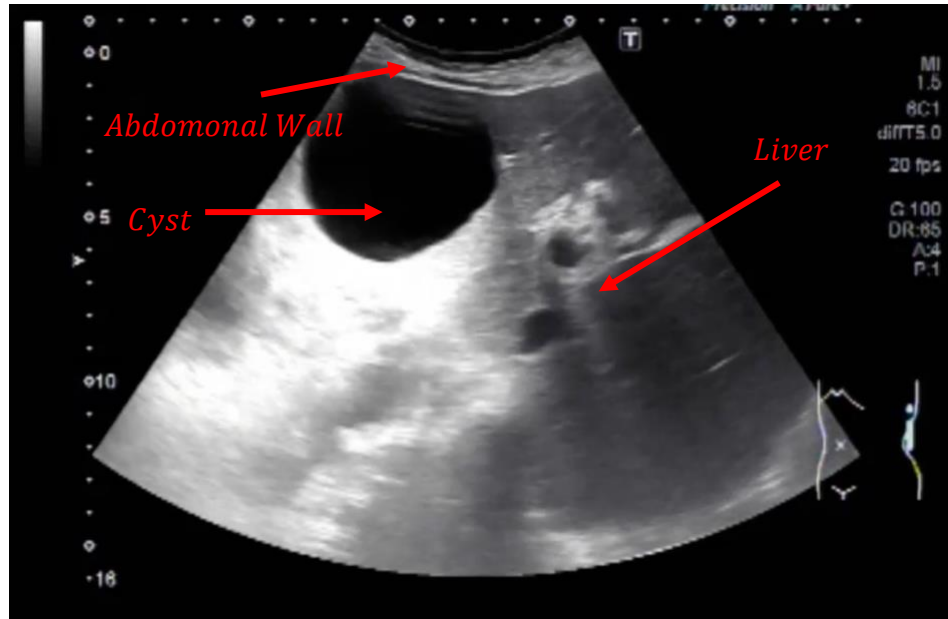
Ultrasound scan of a hepatic cyst.
